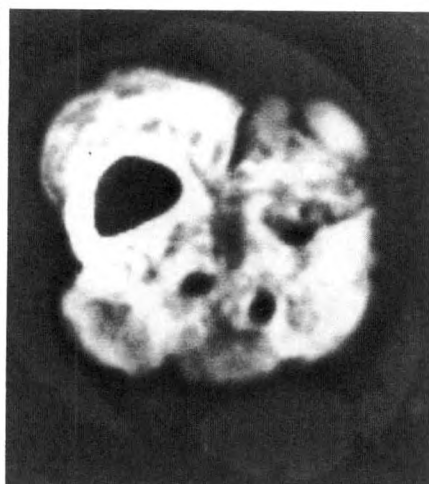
CT shows parosteal osteosarcoma of distal femur with equivocal findings of cortical bone invasion.
